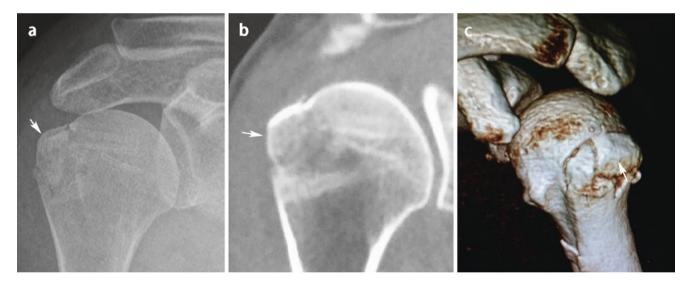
X-ray (a) and CT (b, c) images show the fracture reduction as well
